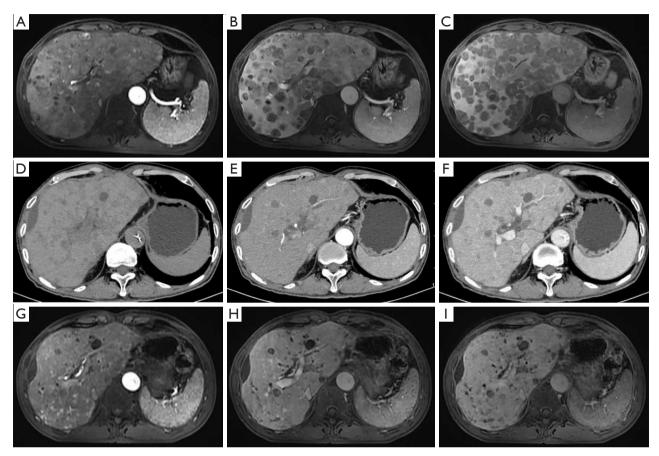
Imaging changes in the treatment of recurrent HCC after liver transplantation. (A-C) Gd-EOB-DTPA-enhanced MRI before treatment (March 15, 2023): Diffuse lesions with partial hemorrhage, with increased size and numbers of nodules. (D-F) Enhanced CT images after the 4-cycle HAIC therapy (August 7, 2023): an irregular margin with decreased and diminished lesions, with diffuse multiple low- and high-density shadows compared to the previous examination (March 15, 2023). (G-I) Gd-EOB-DTPA-enhanced MRI images after 4-cycle HAIC therapy (November 17, 2023): obvious decreased intrahepatic lesions with less partial internal bleeding, compared to the previous examination (August 7, 2023). HCC, hepatocellular carcinoma; Gd-EOB-DTPA, gadolinium-ethoxybenzyl diethylenetriamine pentaacetic acid; MRI, magnetic resonance imaging; CT, computed tomography; HAIC, hepatic arterial infusion chemotherapy.
